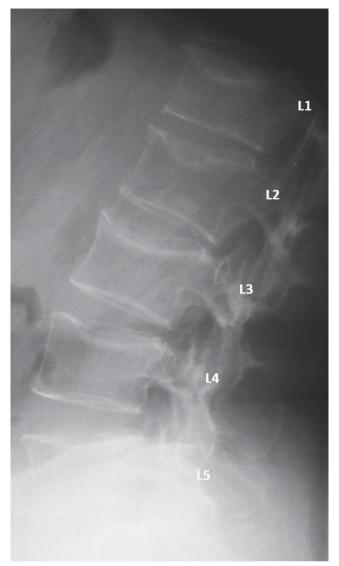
X-ray of lumbar spine showed biconcave deformity of the 1st, 2nd, 3rd and 4th lumbar vertebrae.
